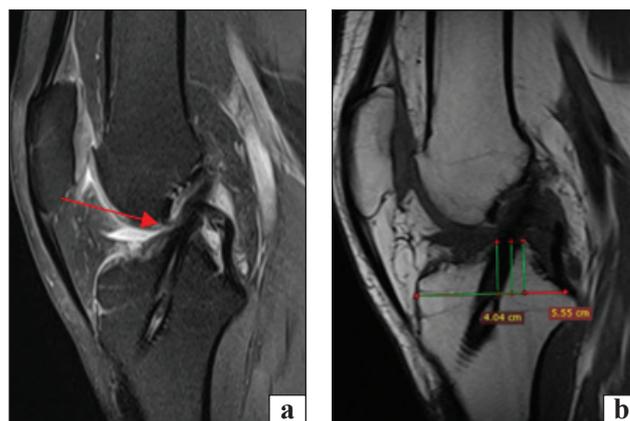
Measurement of the tibial canal entry point on the sagittal projection of MRI imaging (a). Sagittal projection in T2 mode, the arrow indicates the integrated ACL graft (b)
